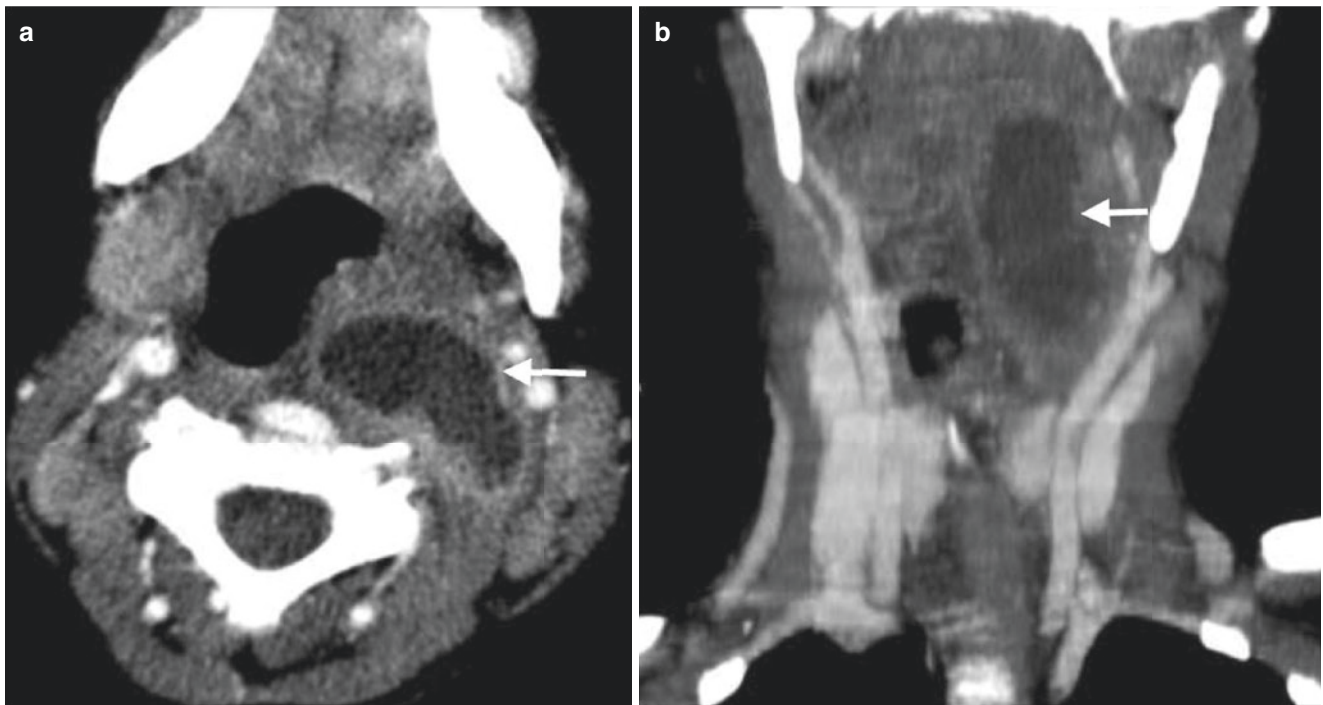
Left parapharyngeal abscess. Axial contrast-enhanced CT image (a) and coronal reconstructed CT image (b) show a well-defined, rim-enhancing, low-attenuation fluid collection (*arrow*) in the left parapharyngeal space. The airway is patent but displaced to the right
